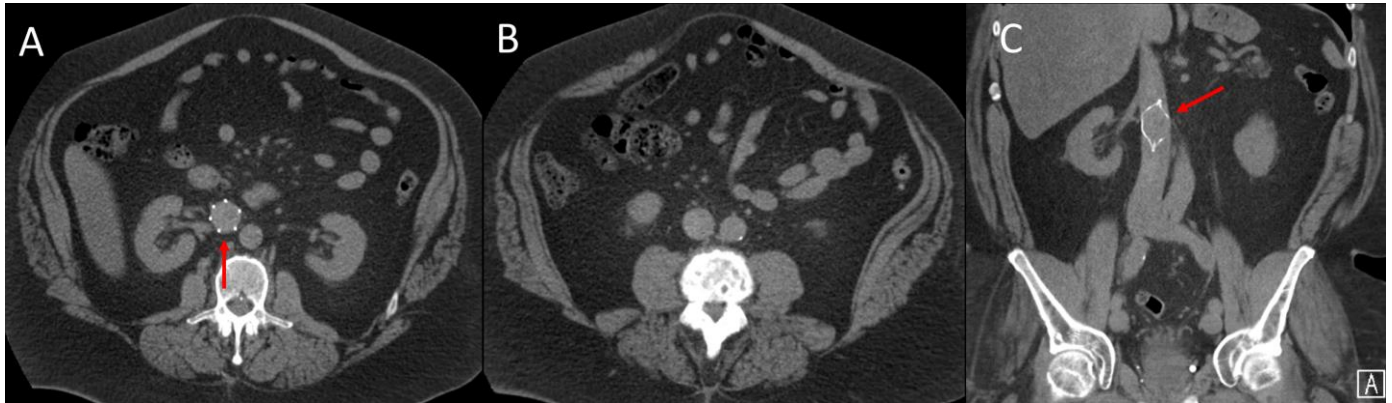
61-year-old man with no acute findings on initial unenhanced CT.
